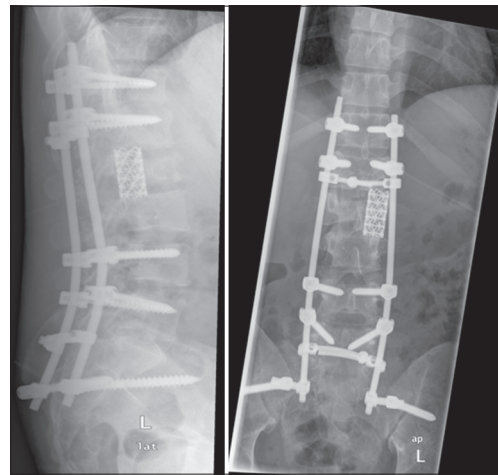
AP and lateral postoperative lumbosacral radiographs
